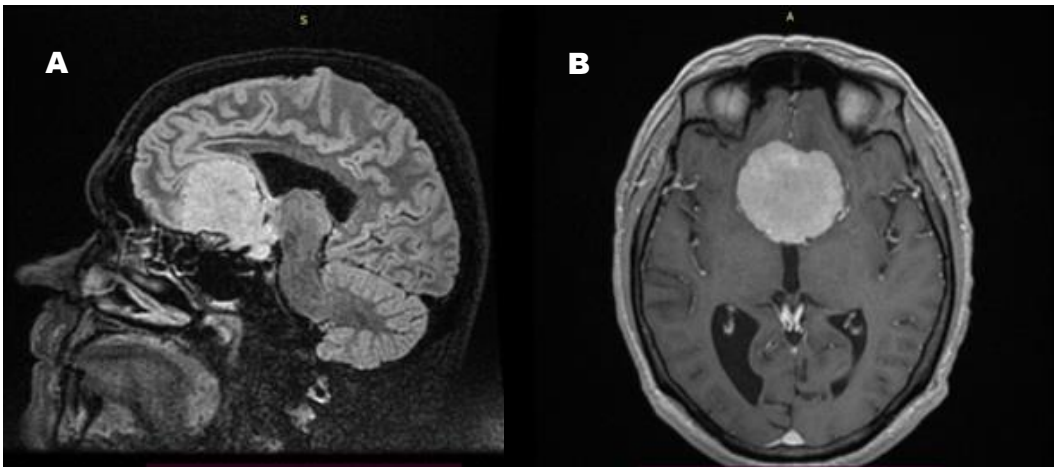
Craniocerebral Magnetic Resonance Imaging (MRI) of a parasellar meningioma. (A) sagittal section.; (B) axial section.
